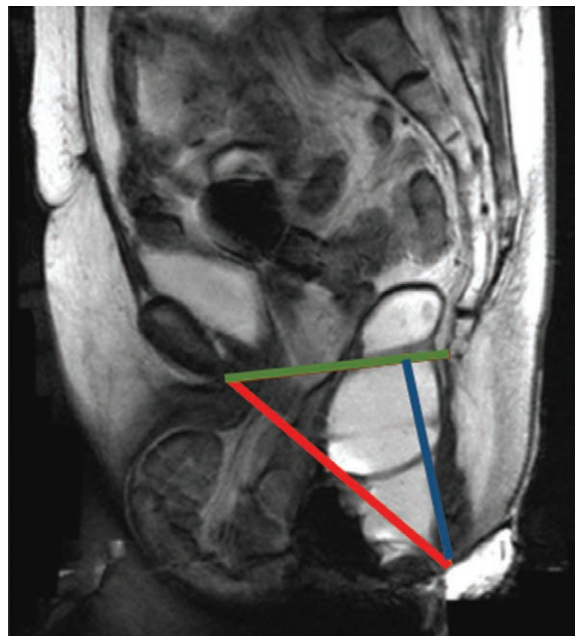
Perineal descent with a grade 3 enterocele (small bowel is below pubococcygeal line) and grade 4 vaginal prolapse (complete eversion). Also note that the H line (red) is widened and the M line (blue) is elongated. Image reprinted with permission from Magnetic Resonance Imaging Clinics of North America 2013;21:427–445.
